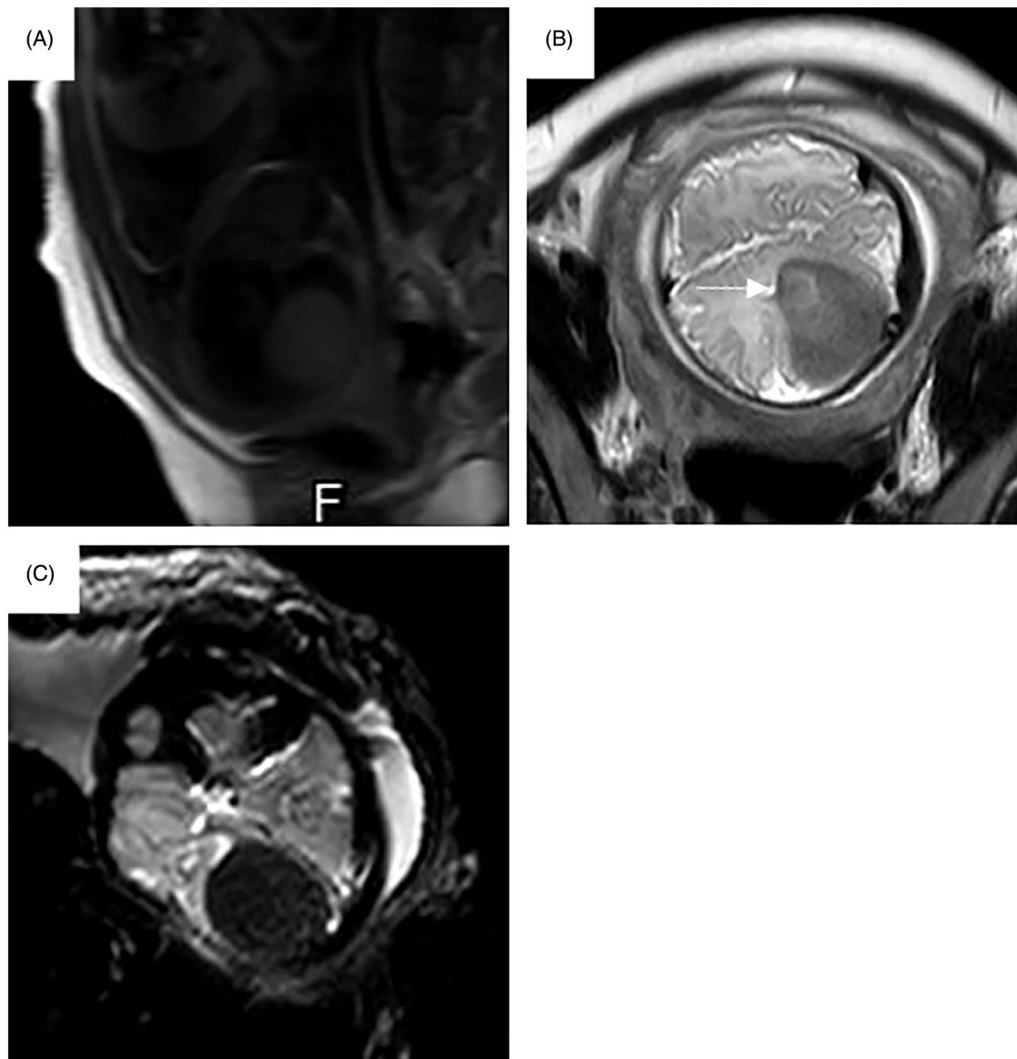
Magnetic resonance imaging. (A) Sagittal T1-weighted image shows a large hypointense signal mass in left temporal lobe. (B) Axial T2-weighted image shows the heterogeneous mass replacing normal brain tissue and resulting in a midline shift and higher T2 intensity areas (arrow) can be seen in the mass. (C) Diffusion weighted imaging shows hypointensity.
